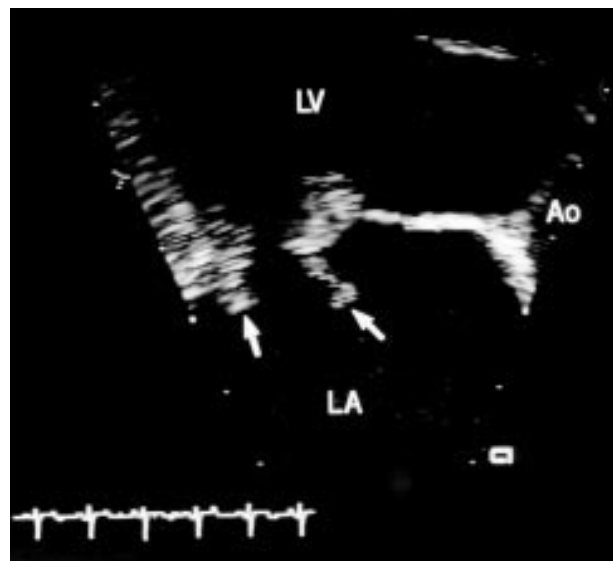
Transoesophageal echocardiographic view of the left atrium (LA), left ventricle (LV) and aorta (Ao) in a patient with bileaflet mitral valve flail segments (arrows) and ruptured chordae.
